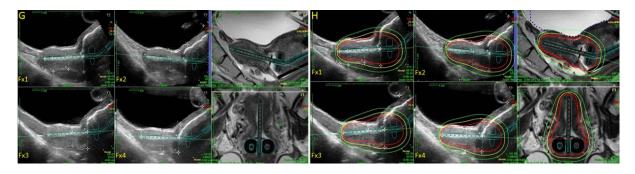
Ultrasound verification and MRI evaluation
